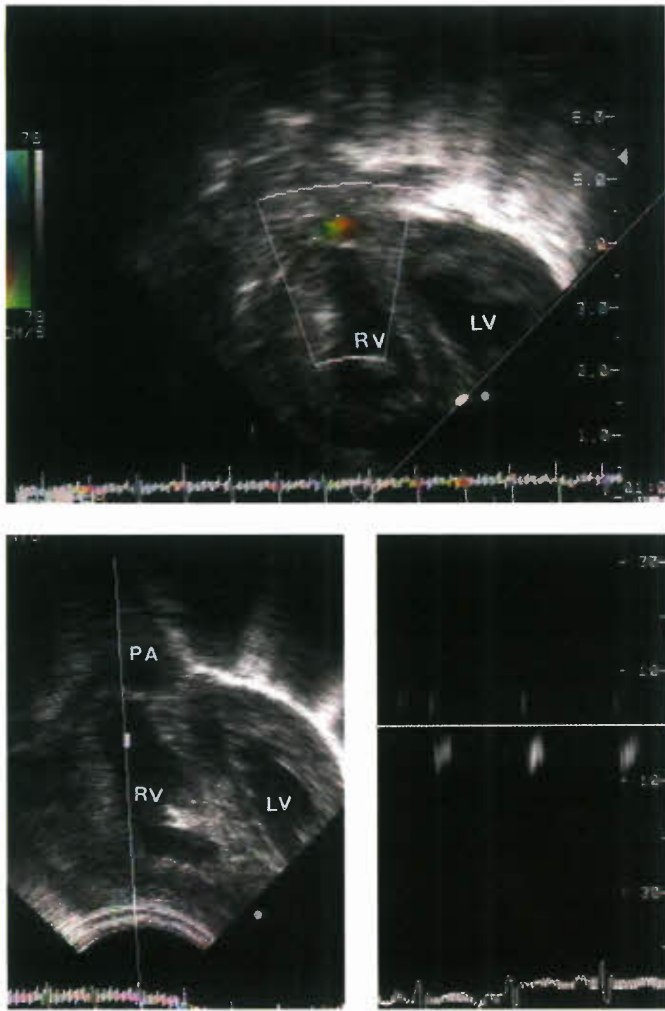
Subcostal view demonstrating an imperforate valve that was subsequently dilated at cardiac catheterization. Note the lack of forward flow in the infundibular region. Upper panel: Color flow Doppler. Lower panel: Confirmed with pulsed Doppler LV, left ventricle; PA, pulmonary artery; RV, right ventricle. (Figs. 41.8 through 41.11 kindly provided by Dr. Jeffrey Smallhorn, Director of Echocardiography, Division of Cardiology, University of Alberta, Canada.)
